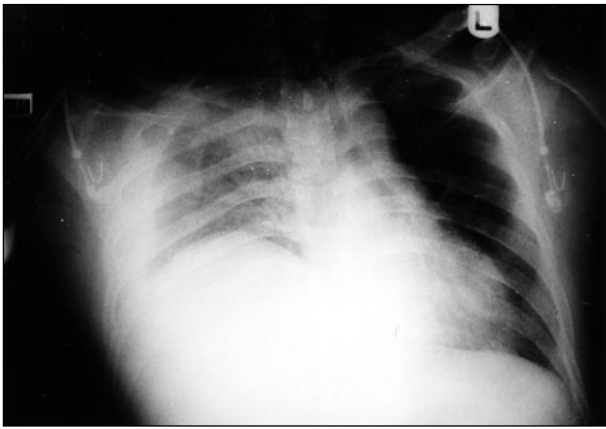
Chest X-ray showing right hemi-diaphragm elevation with haziness of the right pleural space.
